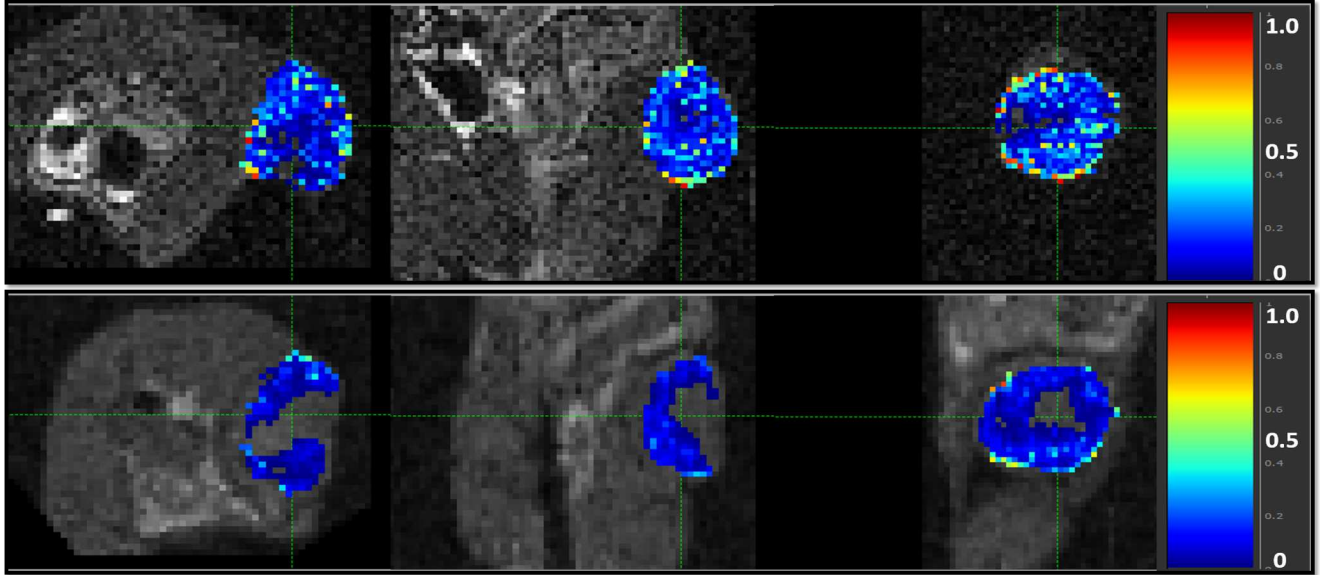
DCE-MRI overlaid with the descriptor maps  $cell_h$  for  $\tau_2$  (top row) and  $\tau_3$  (bottom row) for Case 1, used for the registration between  $\tau_1/\tau_2$ ; and  $\tau_2/\tau_3$  and  $\tau_1/\tau_3$ , respectively.
